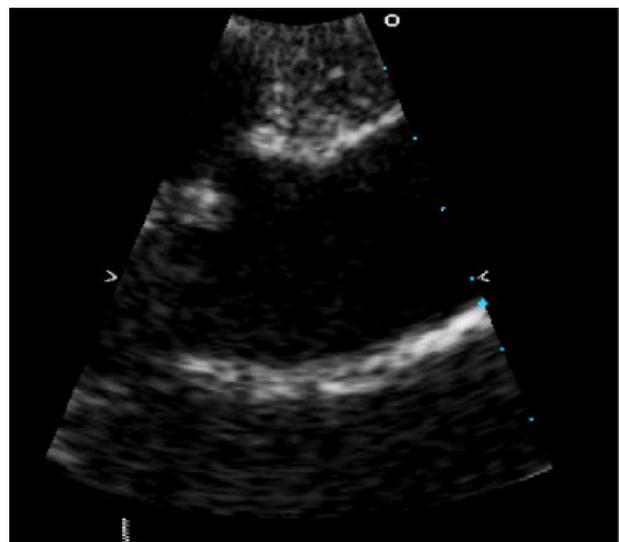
The left parasternal long axis view demonstrates pear-shaped “pouching” of the sinus of Valsalva in a 41-year-old woman with hypermobile EDS.
